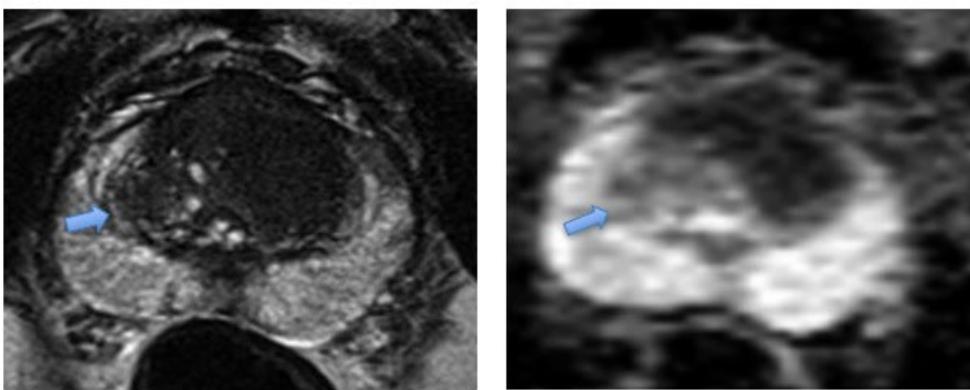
PI-RADS V lesion in the transition zone. (Left) Axial T2-weighted sequence (dominant sequence for the transition zone) showing a circumscribed lenticular 20 mm hypointense mass in the anterior transition zone. (right) ADC map correspondingly shows focal markedly hypointense signal intensity of the mass.
